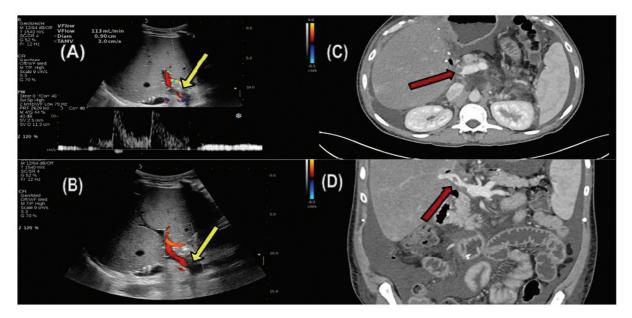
A 44-year-old male with living donor liver transplantation (LDLT) 1 year back. Color Doppler images (A and B) show absence of wall-to-wall color in the main portal vein (yellow arrow) secondary to eccentric echogenic thrombus. Reduced flow volume in main portal vein was documented with spectral analysis. Contrast-enhanced computed tomography (CECT) axial and coronal images (C and D) depict partial eccentric hypodense thrombus in the extrahepatic portions of main portal vein (red arrow), respectively.
